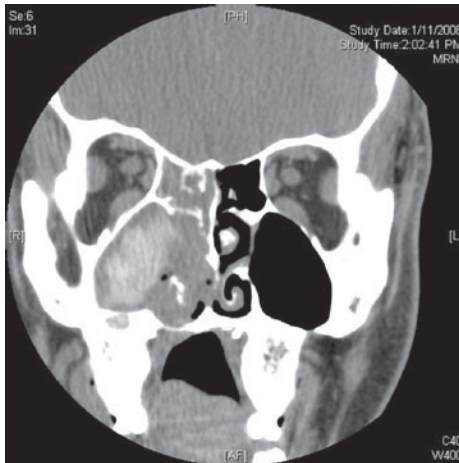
This coronal CT in soft tissue windows is characteristic of a patient with allergic fungal sinusitis and polyposis. Note the unilateral disease, the soft tissue attenuation characteristic of nasal polyposis as well as accumulation of allergic mucin within the maxillary sinus and among the polyps that presents as a differential density due to its increased density relative to soft tissue
